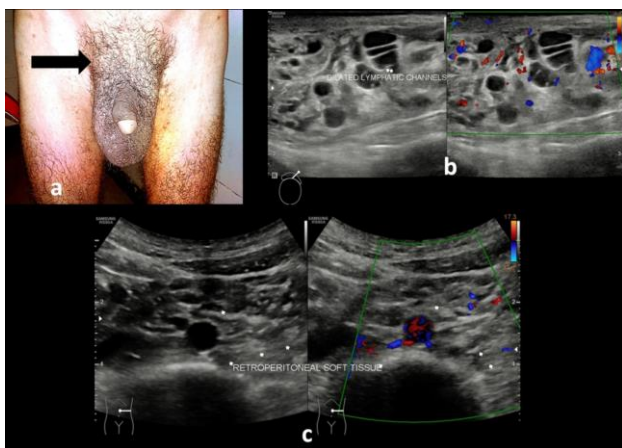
(a) Swelling at scrotal root (marked by black arrow). (b) USG and Doppler axial images of abdomen showing multiple dilated and tortuous channels in scrotum with no internal vascularity, (c) similar channels are also seen in retroperitoneum.
